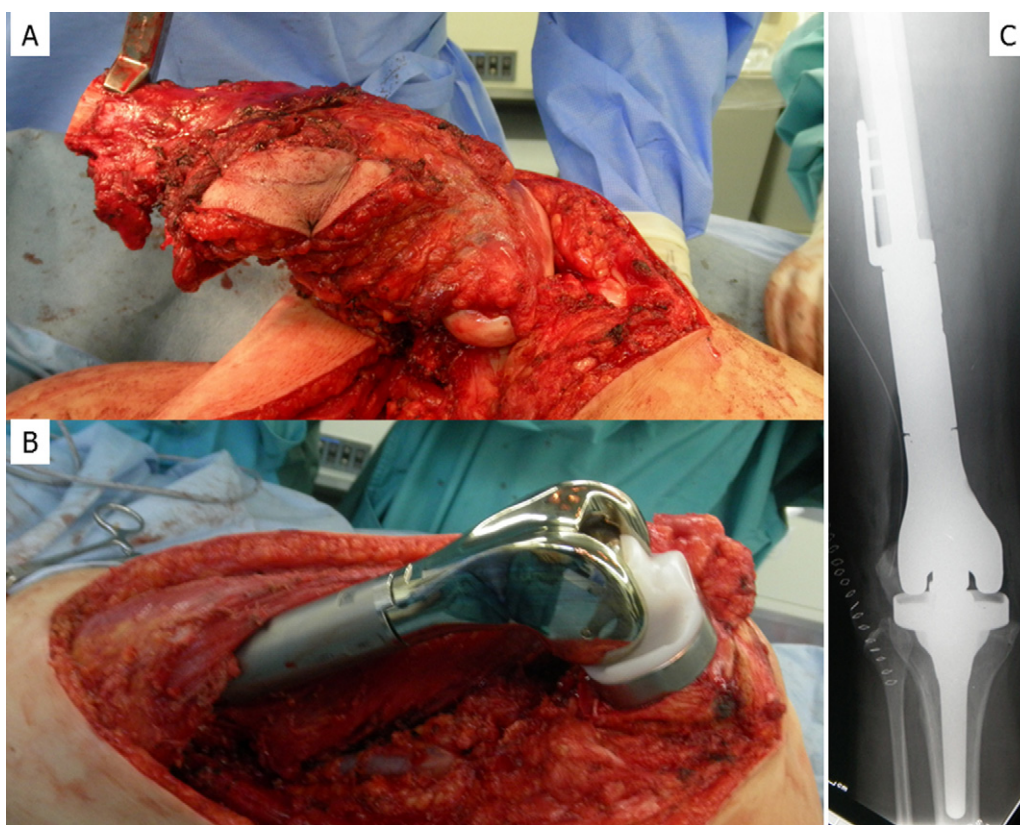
(A) Wide resection was performed. (B) Distal portion of the right femur was replaced by Kyocera Limb Salvage (KLS) System. (C) Post-operative plain radiography shows that distal femur was resected and replaced by prosthesis.
